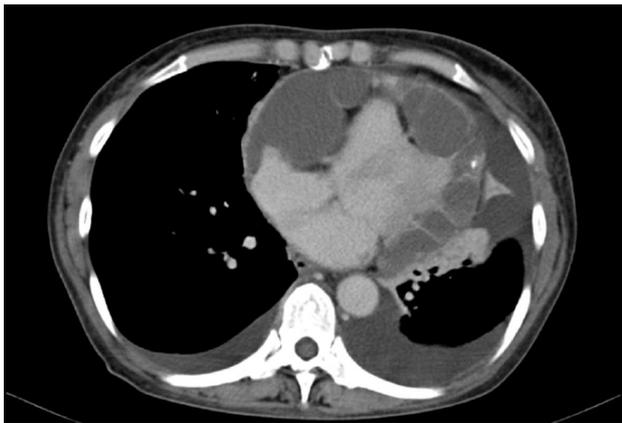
A computed tomography scan demonstrating pericardial effusion with cardiac tamponade.
